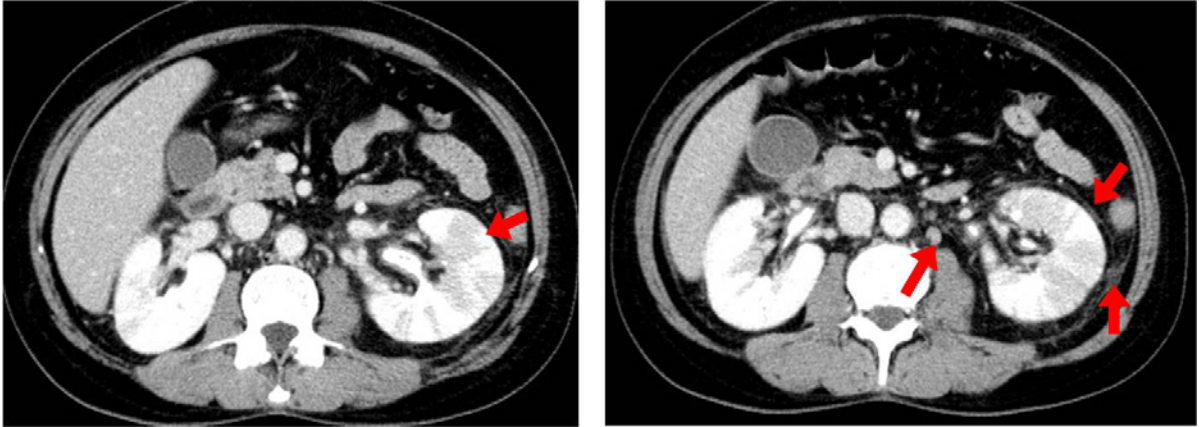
Abdominal CT scan showing renal enlargement, thickening of Gerota's fascia, bridging septa of the peri-nephric fat, and a wedge-shaped zone of poor enhancement consistent with pyelonephritis (arrows).
